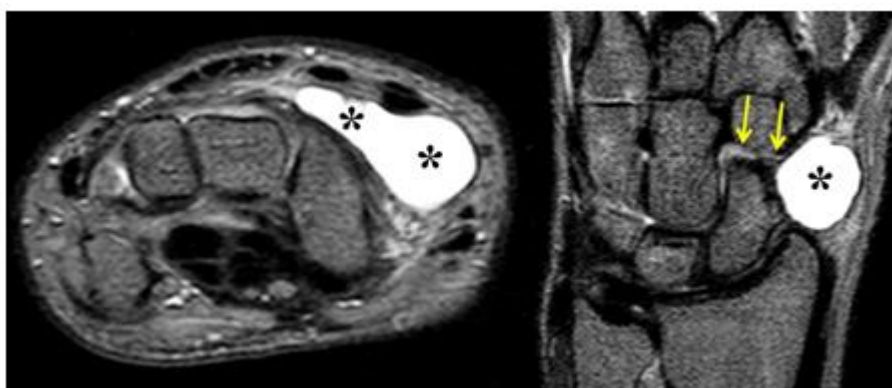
Axial and Coronal T2-weighted fat-suppressed MRI shows a well-defined, hyperintense cystic structure (asterisk) along the dorsal aspect of the wrist with a communicating stalk/pedicle (arrows) arising from the scaphotrapezotrapezoid joint. The marked hyperintensity indicates fluid content. Findings consistent with Ganglion cyst.
